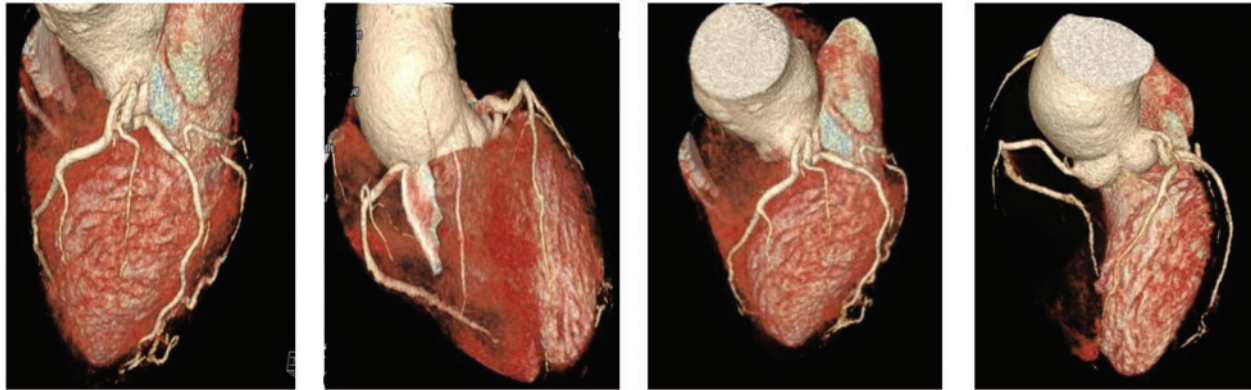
Coronary computed tomography angiography showing normal epicardial coronary arteries.
